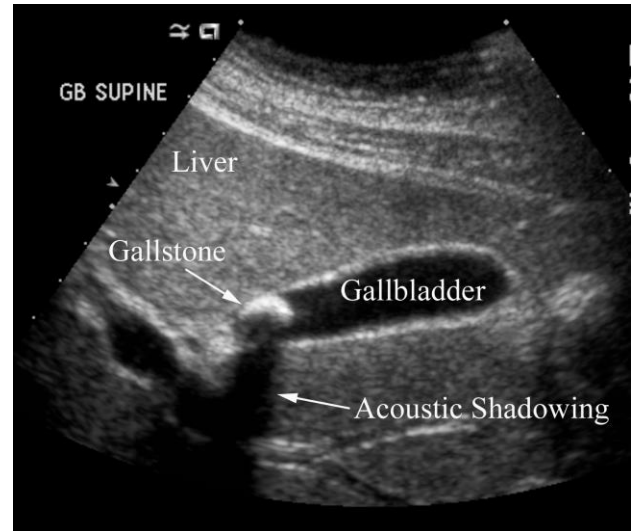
Gallstone disease in a 31 year old woman with right upper quadrant pain. Ultrasound demonstrates a hyperechoic, shadow casting structure within the gallbladder diagnostic of a gallstone.
